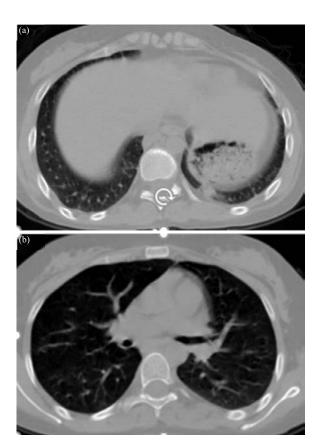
(a-b): Follow up axial CT images show less residual GGO
